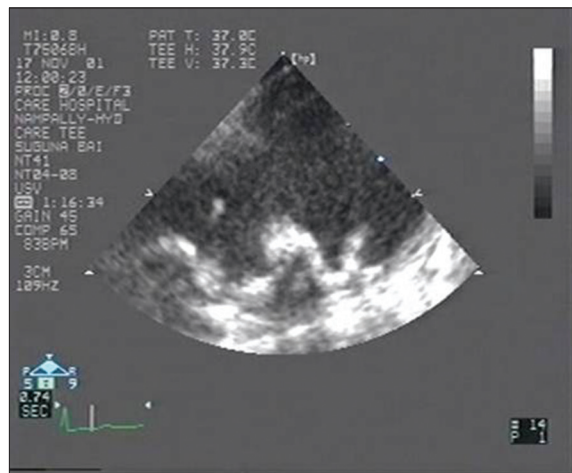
Grade V atheroma (mobile plaque) on transoesophageal echocardiography
